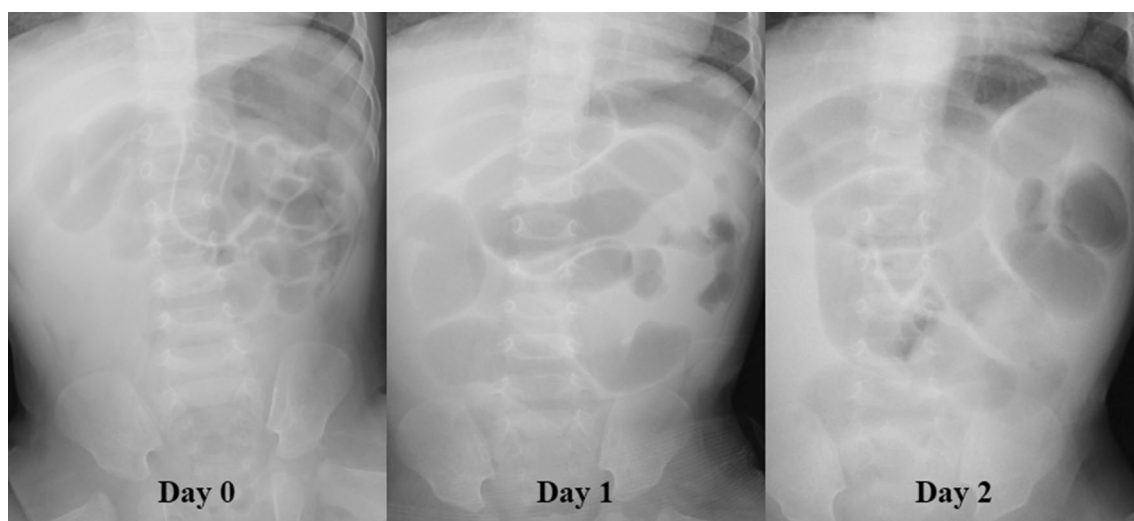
Abdominal X-ray findings
